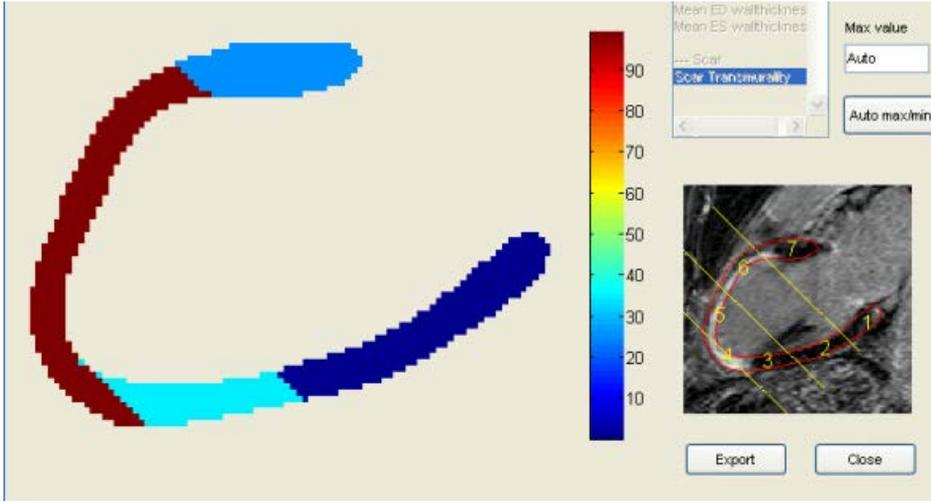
Transmuralty of scar calculated from Late Gadolinium Enhanced image (2 chamber view). Scar is 100 % transmural along the middle and apical part of the anterior wall. Calculation performed with the “Segment” software. Reprinted with permission from *Cardiovascular Ultrasound*.
